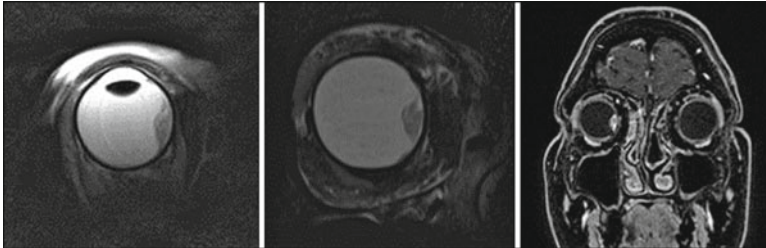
MRI of a patient with a choroidal melanoma. *Left:* $T2$ -weighted axial image taken with a surface coil. *Middle:* another $T2$ -weighted coronal image taken with a
